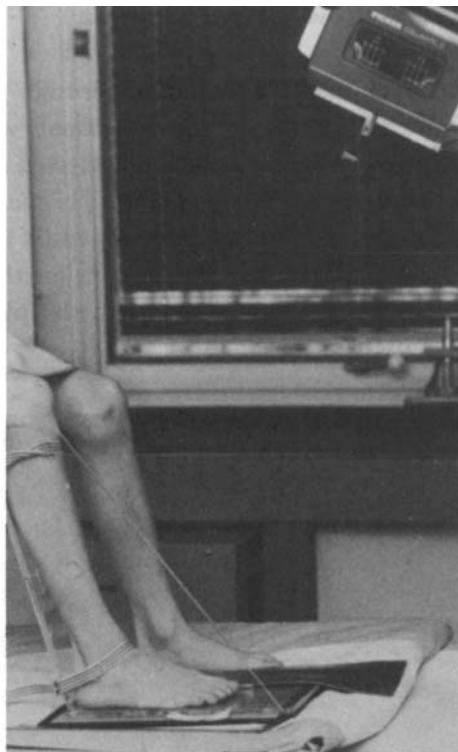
Set-up for the dorsiplantar radiograph.
